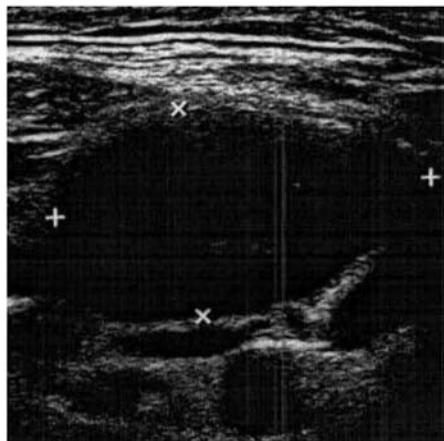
Cropped image of a print-out of the B-scan ultrasonogram of the left neck. The anechoic oval lesion appeared to have distinct borders. The lesion had displaced the sternocleidomastoid muscle (left). Its ultrasonographic appearance makes invasive growth of the lesion unlikely.*
